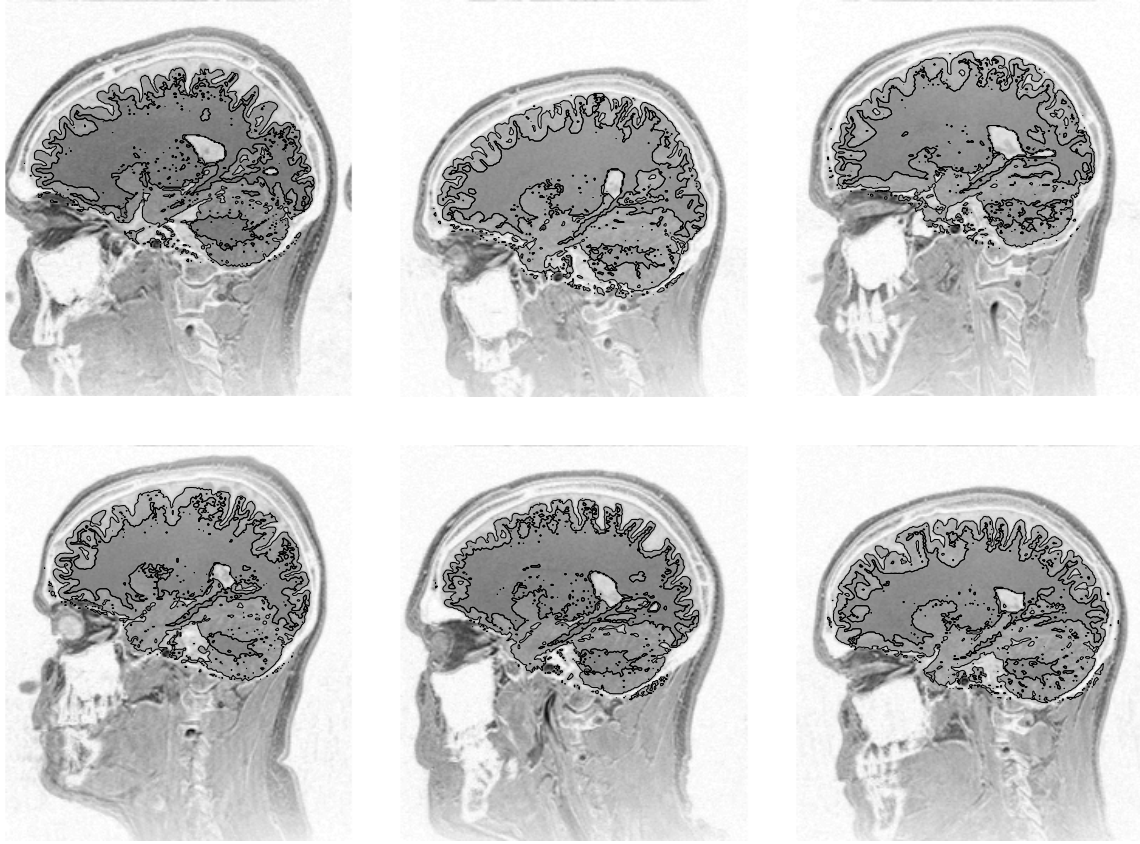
A single sagittal slice through six T1-weighted images (2 Tesla scanner, with an MPRAGE sequence, 12° tip angle, 9.7ms repeat time, 4ms echo time and 0.6ms inversion time). Contours of extracted grey and white matter are shown superimposed on the images.
